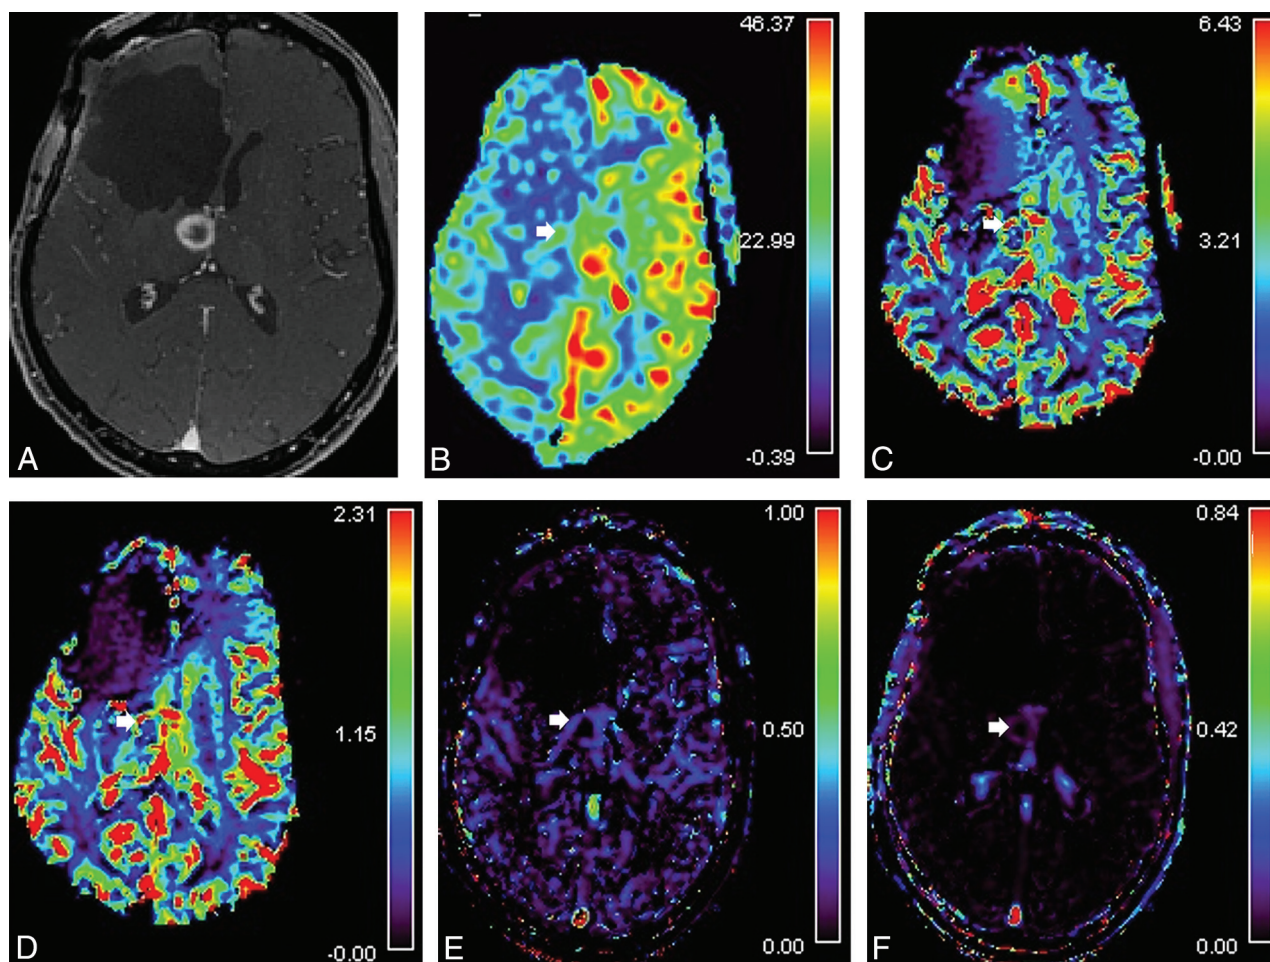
Sample of a case of recurrent glioblastoma multiforme with a false-negative ASL study due to probable ineffective labeling. Patient had a history of a right frontal grade IV glioma and had undergone resection and chemoradiation 3 years earlier. A, Axial T1-weighted image shows a newly enhancing lesion in the right anterior thalamus. B, ASL-derived CBF reveals a low CBF value in the enhancing lesion (arrow). The CBF in the right hemispheric cortex is lower than on the left side, presumably due to ineffective labeling from dental hardware. DSC MR imaging demonstrates a high, uncorrected rCBV value (C) and leakage-corrected rCBV value (D) at the rim of the enhancing lesion (arrow). DCE MR imaging using MOLLI T1 mapping shows high Vp (E) and K^{trans} (F) values in the lesion (arrows). Pathology confirmed glioblastoma recurrence.
